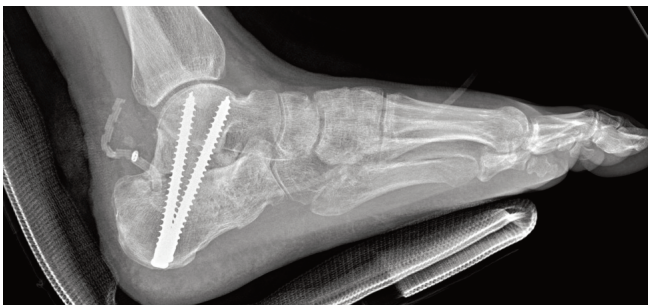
Postoperative radiograph showing two 6.5 mm non-cannulated screws fixating the subtalar joint with joint depression corrected with a bone block.
